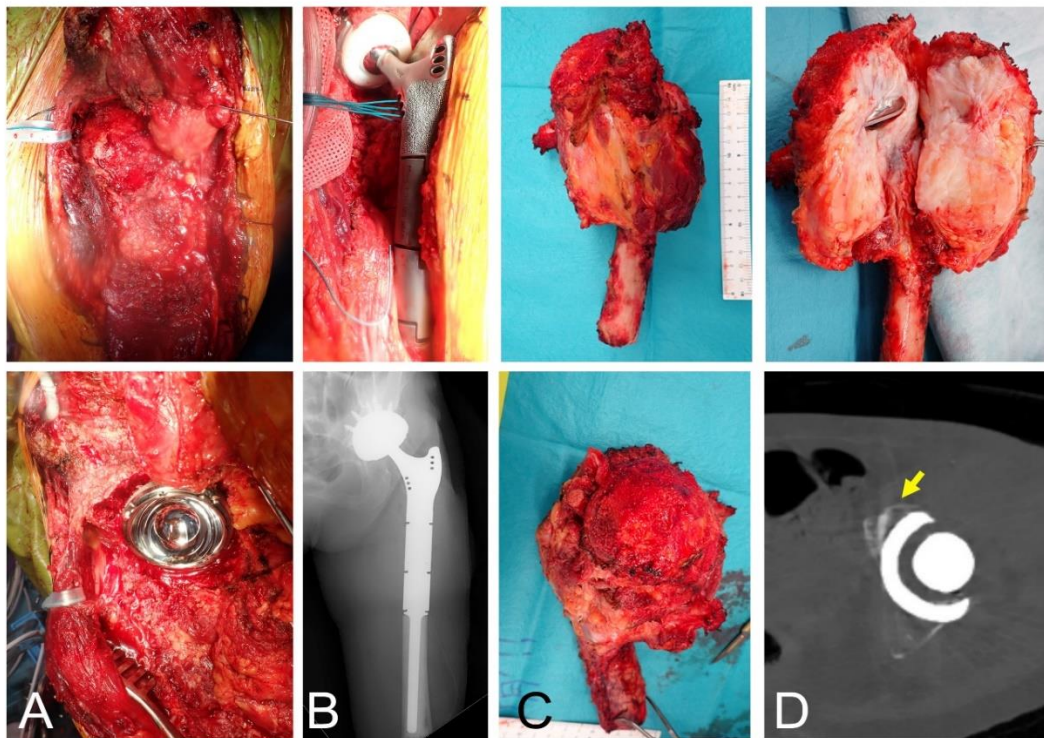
After complete acetabular resection (A-top), a cementless acetabular outer cut was made (A-bottom). A prosthesis was implanted (B-top; its postoperative plain radiograph is shown, B-bottom). The resected tumour was covered by soft tissue and bone (from anterior: C-top; superior-posterior: C-bottom). The cut surface shows that the tumour extended into the hip joint (D-top). Computed tomography shows the preserved anterior acetabular column (yellow arrow), and the defect is filled with beta-TCP (D-bottom)
